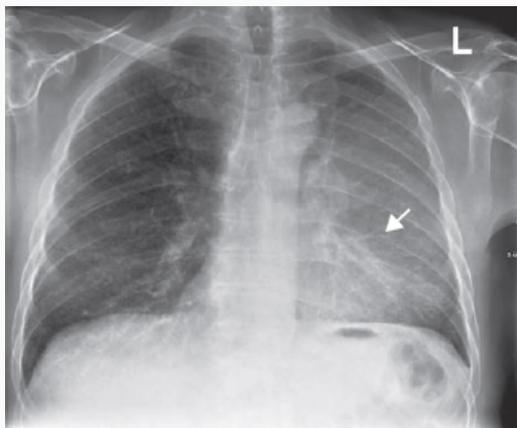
Chest radiograph showing a left upper lobe collapse due to a bronchial carcinoma. A veil-like opacity is obscuring the left heart border (white arrow).
